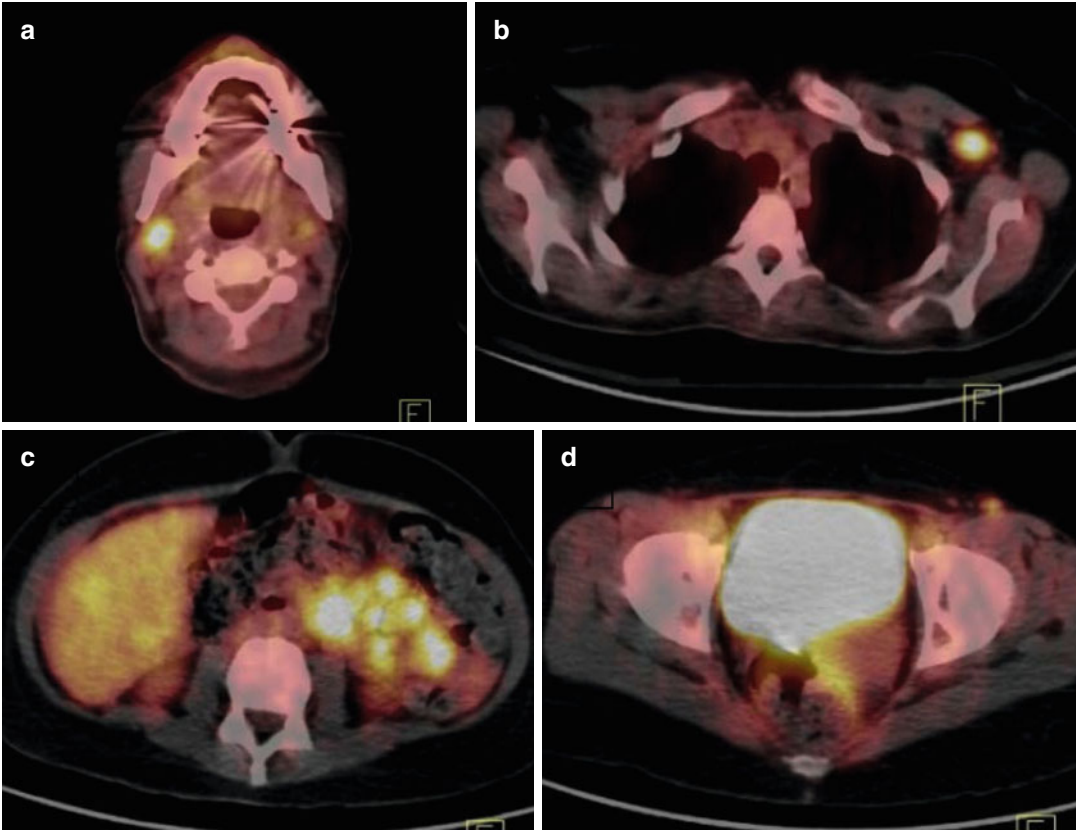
PET/CT shows hypermetabolic submandibular (a), left axillary (b), mesenteric (c), and left inguinal (d) lymph nodes. Lesions with increased metabolic activity are seen in the liver and spleen (e–h)
